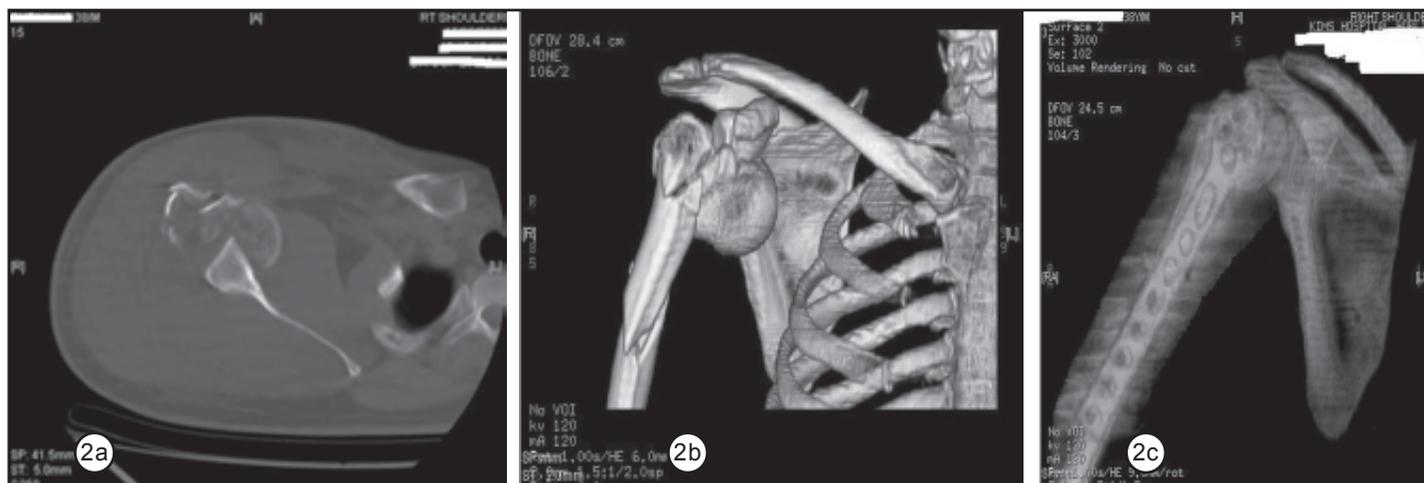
Pre-operative CT scan; Figure 2b : Pre-operative 3D CT scan; Figure 2c : Post-operative CT scan (Case 2)
